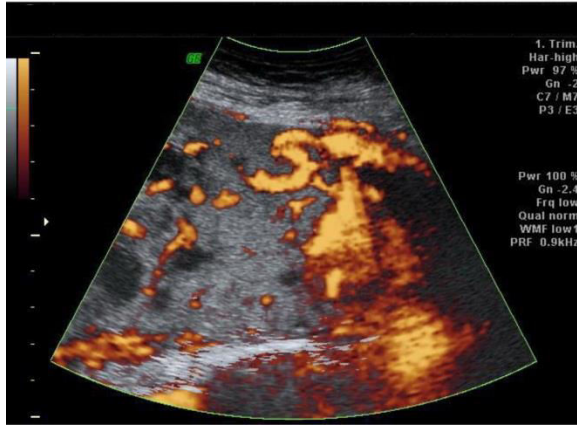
Placenta increta in 29 year old pregnant female patient at 25 weeks of gestation came for routine antenatal examination with history of previous 4 C.S. Color Doppler shows hypoechoic spaces which are vascular and therefore represent placental lacunae giving the characteristic "swiss cheese appearance". Note the presence of hypervascularity of the interface between the uterine serosa and the bladder wall. Patient was found to have placenta accreta at delivery.
